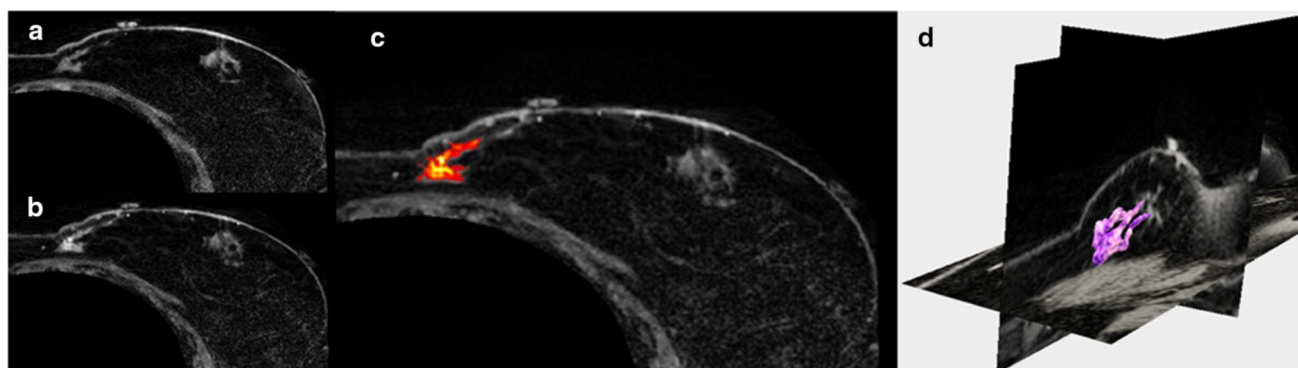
Axial slices of supine MRI of patient volunteer with a precontrast, b post-contrast injection, c contrast-enhanced tumor, and d 3D segmentation of tumor (*magenta*)
